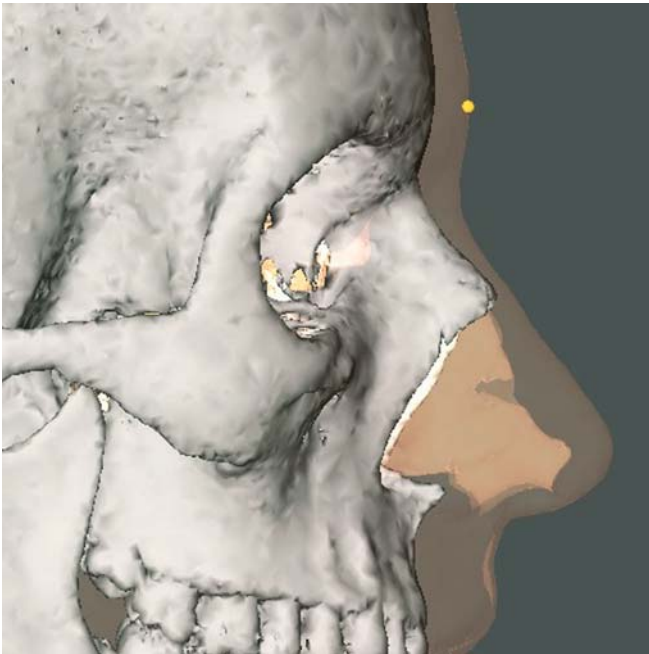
Glabella. Profile view right. Note that the 3-D soft tissue cephalometric glabella landmark is located on the soft tissues and is therefore not identical to the anthropometric glabella landmark, which is the same as the bony Glabella landmark. (3-D CT, transparent soft tissues, patient K.C.)
